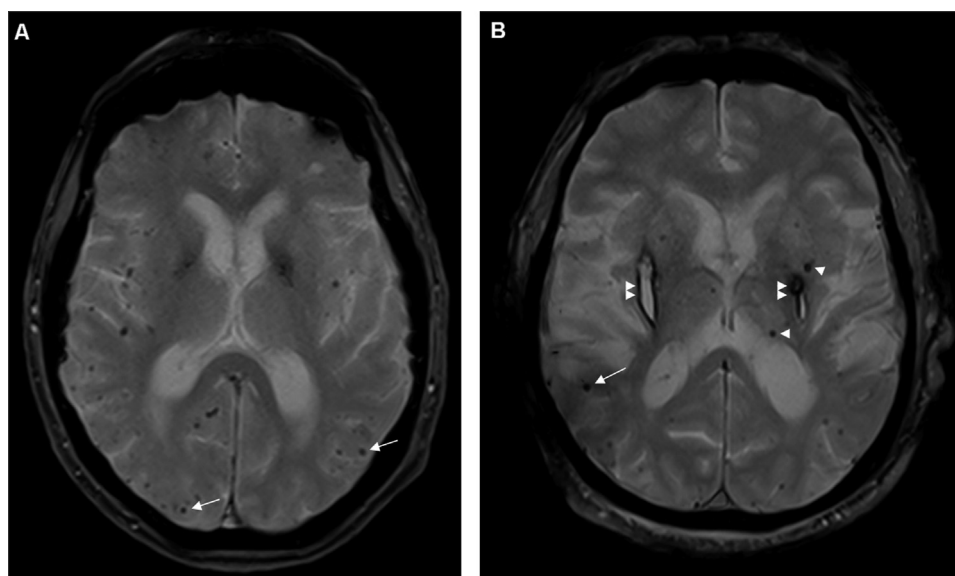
Axial T2* gradient echo-weighted brain magnetic resonance imaging of two patients, showing: (A) multiple bilateral lobar cerebral microbleeds (some are shown with arrows); and (B) both lobar (arrows) and deep (arrow heads) cerebral microbleeds associated with bilateral basal haemorrhages (double arrow heads), suggestive of small-vessel disease.
